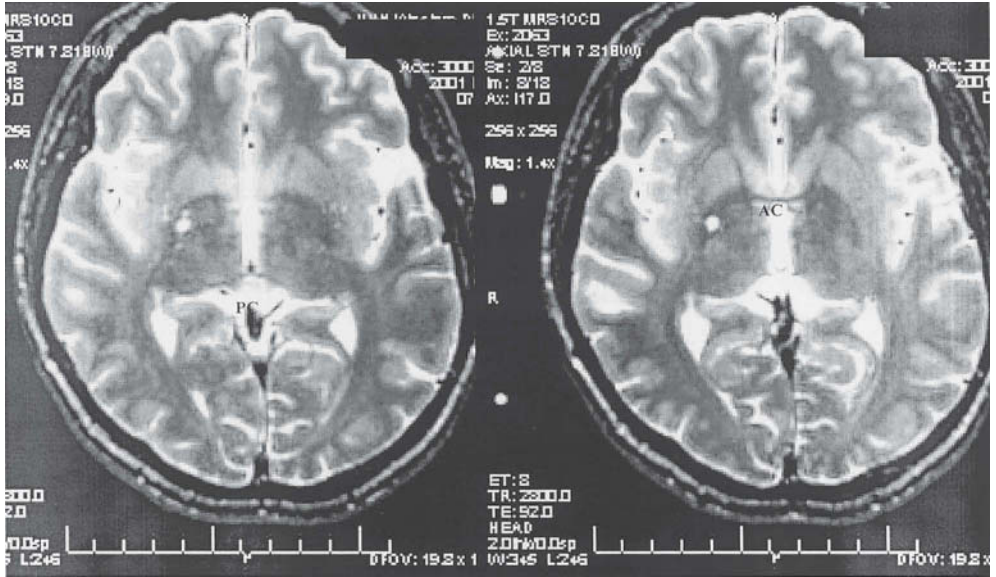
T2-weighted axial sections used to identify the coordinates of the posterior commissure (PC) and anterior commissure (AC) for all indirect targeting methods.
